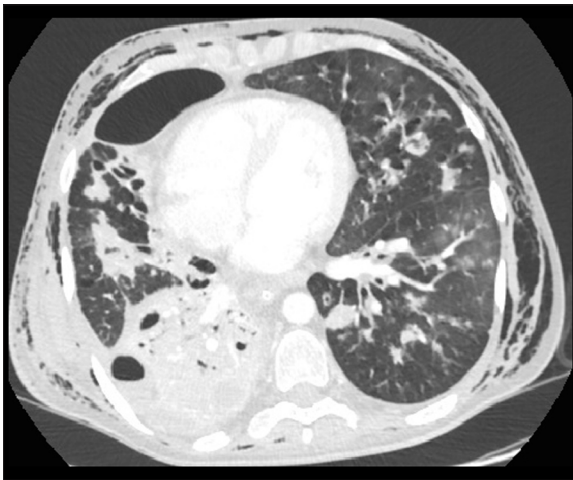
Axial chest CT image after contrast injection depicts complications in the course of CF. Subcutaneous emphysema, right-sided pneumothorax coexisting with right lower lobe atelectasis and widespread consolidation regions in both lungs.
